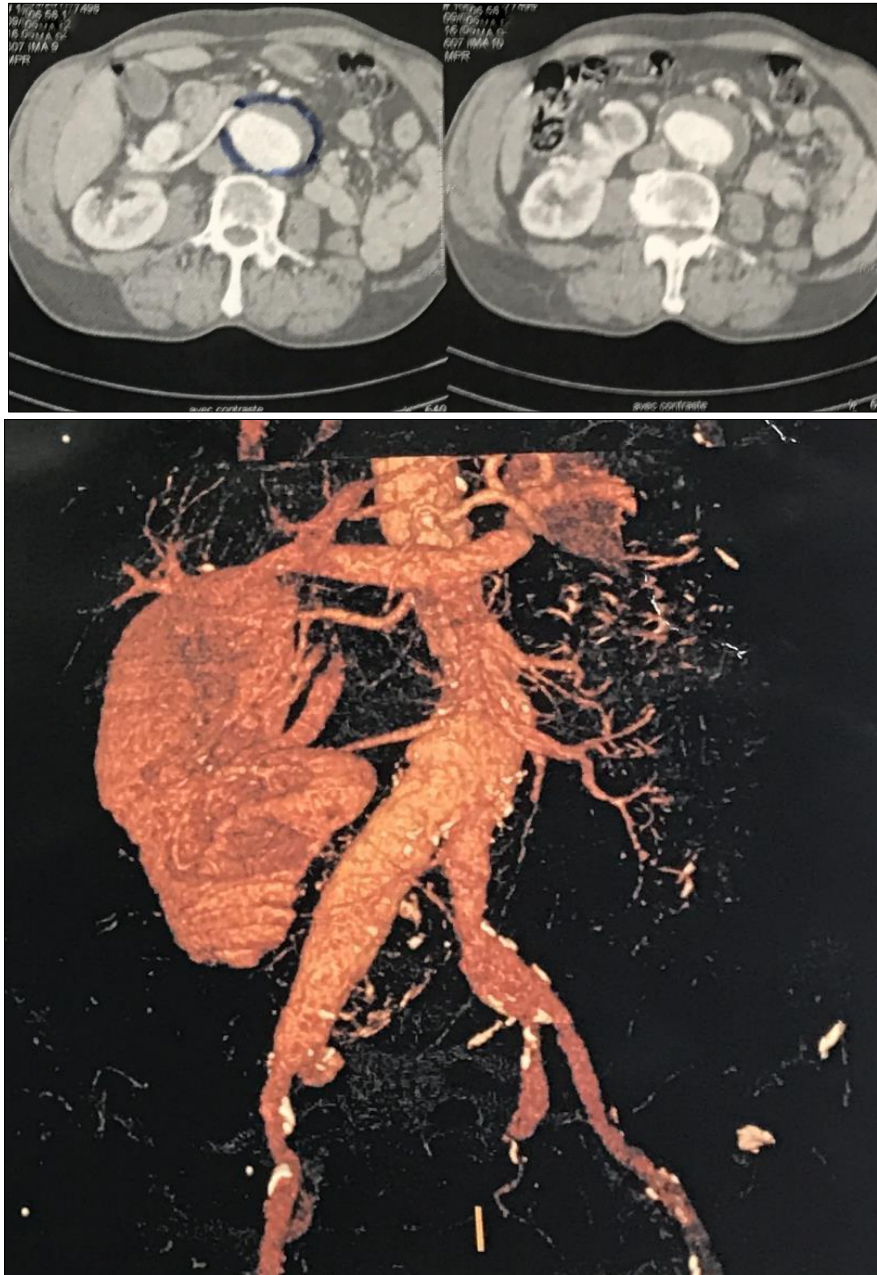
CT angiography with reconstruction showing a juxtarenal abdominal aortic aneurysm associated with a horseshoe kidney
